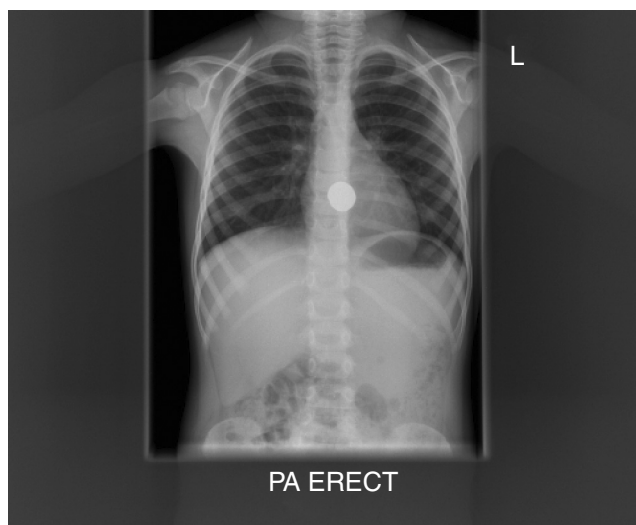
Plain x-ray showing impacted 2 pence coin in the oesophagus in a child. It was retrieved endoscopically
